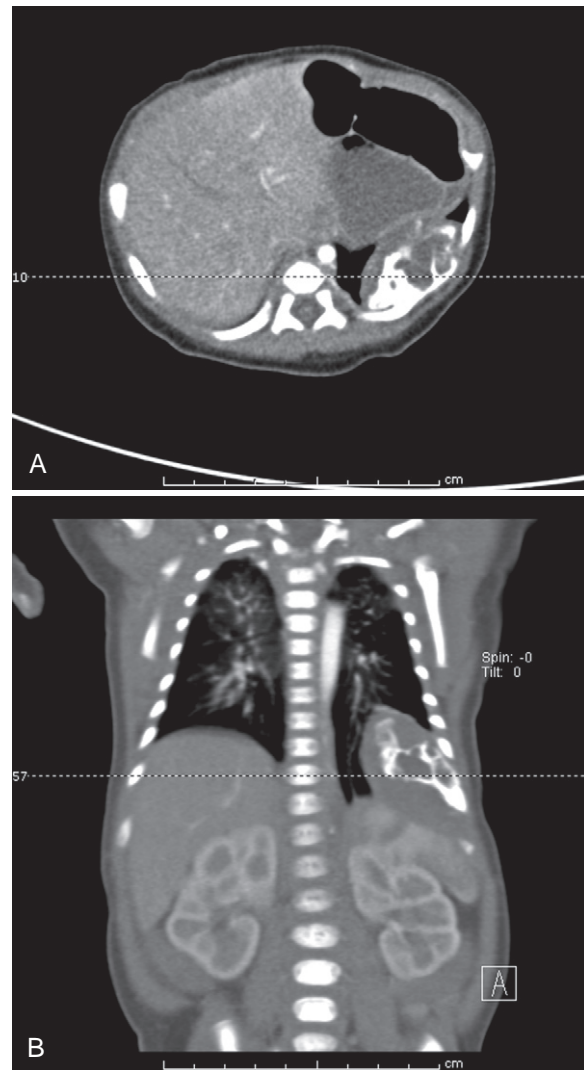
Axial (A) and coronal (B) images of a computed tomography scan of the chest in an infant with a mesenchymal hamartoma.
